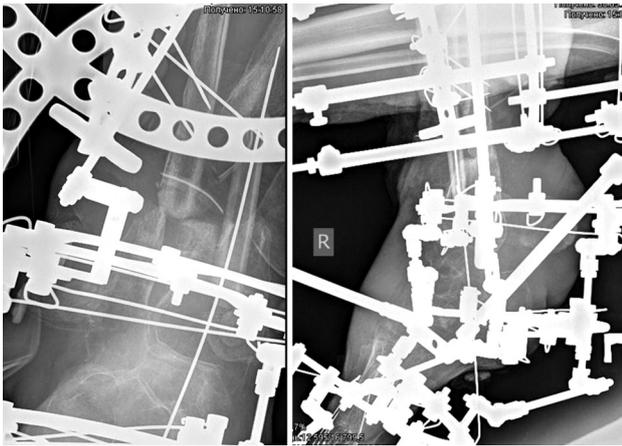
Radiographs of the lower limbs showing fixation of both tibiae following the plasty with a non-free fibular flap
